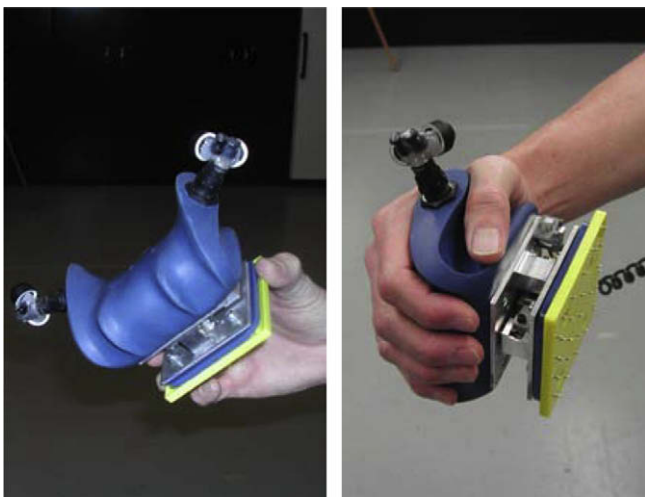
The LiftMate™ handles instrumented with strain gauges and accelerometers for measuring static and dynamic loads and instrumented with ultrasound emitters for tracking hand position.
